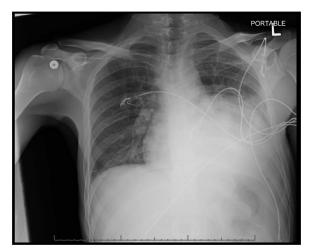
Initial chest X-ray on admission demonstrating a moderate left-sided pleural effusion.
